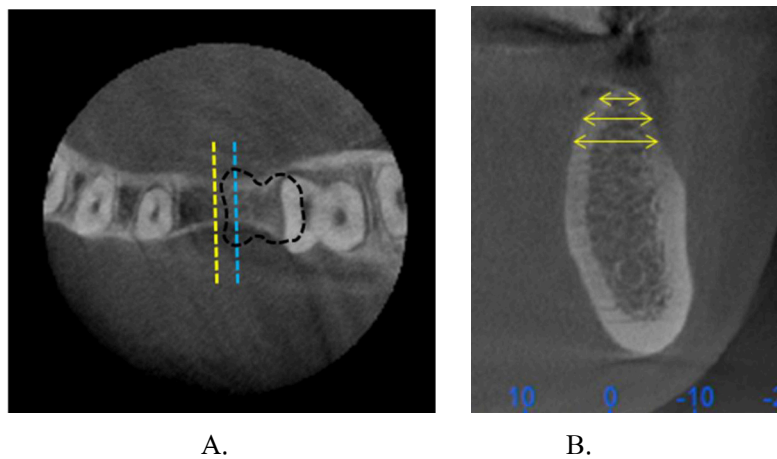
CBCT section at the narrowest of edentulous ridge and at the area that mesial root of mandibular second molar was moved following the treatment plan (A). The bucco-lingual width of alveolar ridge was measured at 4mm, 6mm and 8mm below CEJ (B).
